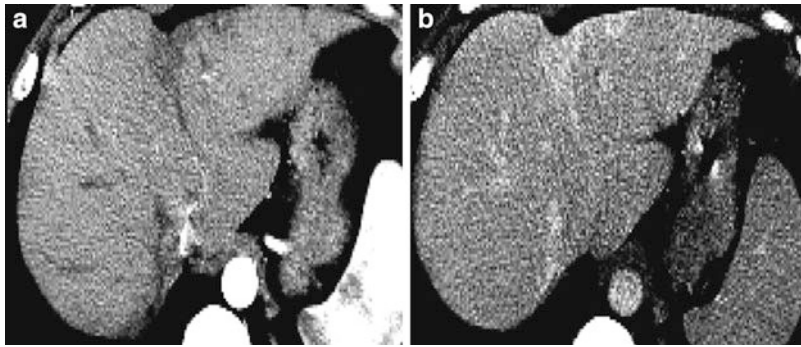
CT scans show focal confluent fibrosis in a cirrhotic liver. (a) Transverse hepatic arterial phase CT image demonstrates low attenuation peripherally in segment IV. Overlying capsular retraction is suggestive of fibrosis, since untreated
